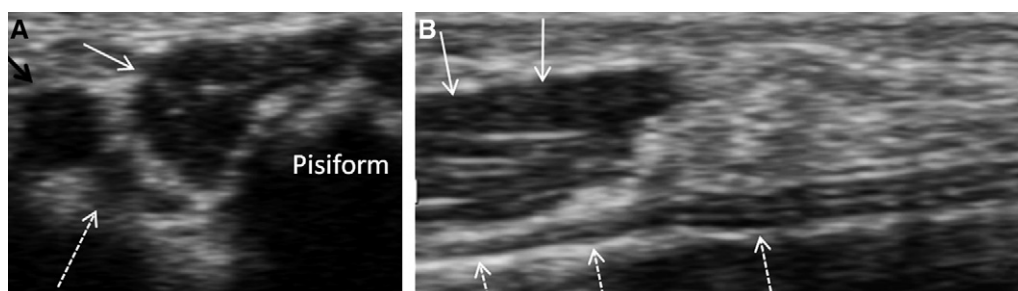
Guyon canal syndrome. Axial (A) and sagittal (B) ultrasound images of the Guyon canal, demonstrating an accessory abductor digiti minimi muscle (white arrows) displacing and compressing the ulnar nerve (dotted white arrows). Ulnar artery (black arrow).
